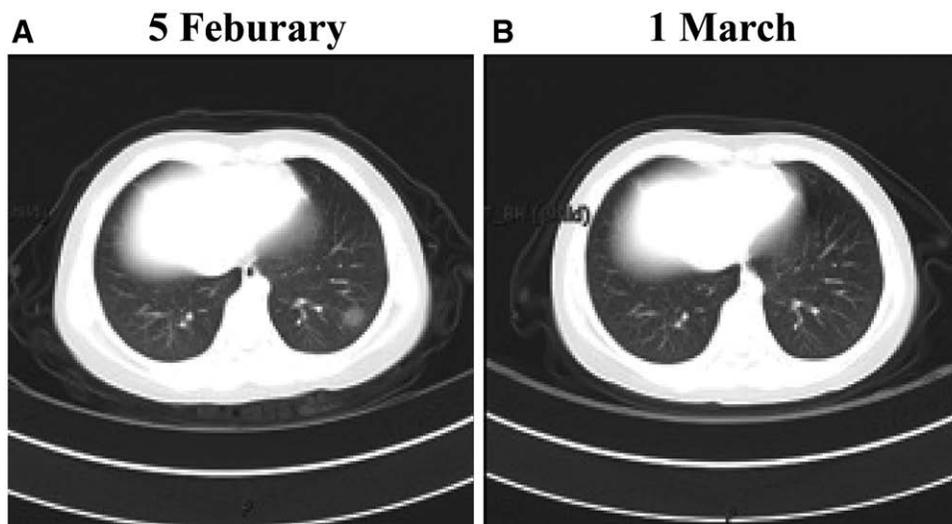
Changes in chest computed tomography images during two admissions of this patient. (A) First and (B) second.
